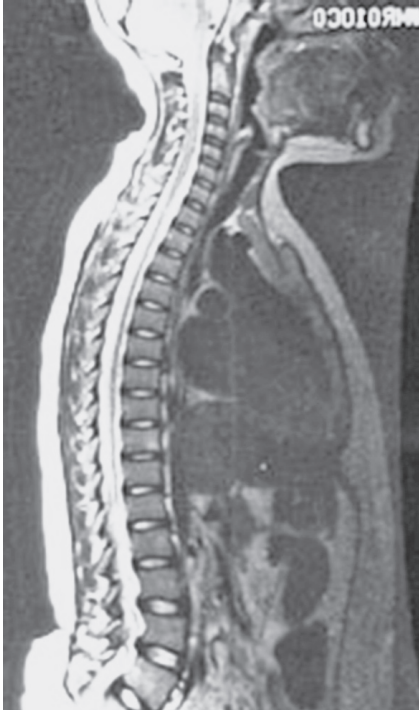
Side-Scan (cross section) MRI of the spine of a 7-year-old boy with 30° scoliosis [11]
